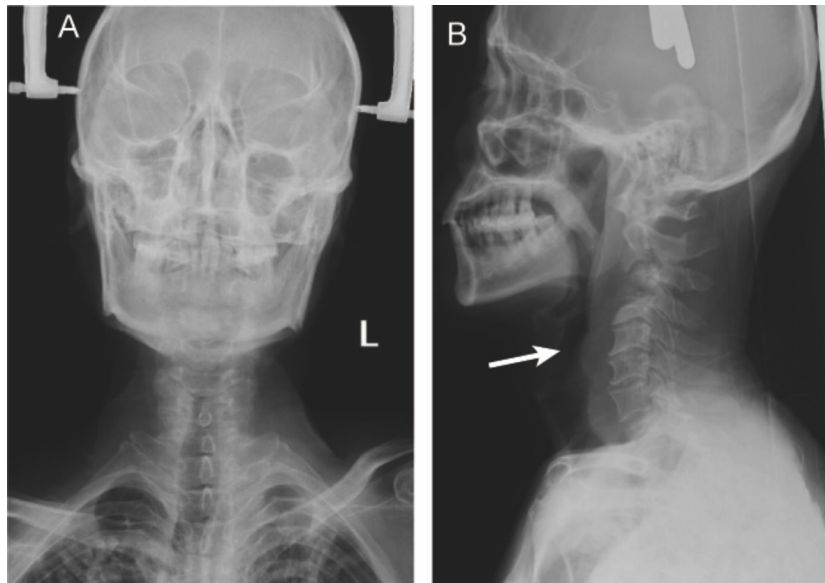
Positive and lateral X-ray images of the cervical spine after traction. A, Orthogonal view of the cervical spine after 6 Kg of cranial traction. B, Lateral image with arrows indicating bone destruction and C3-C4 vertebral collapse.
